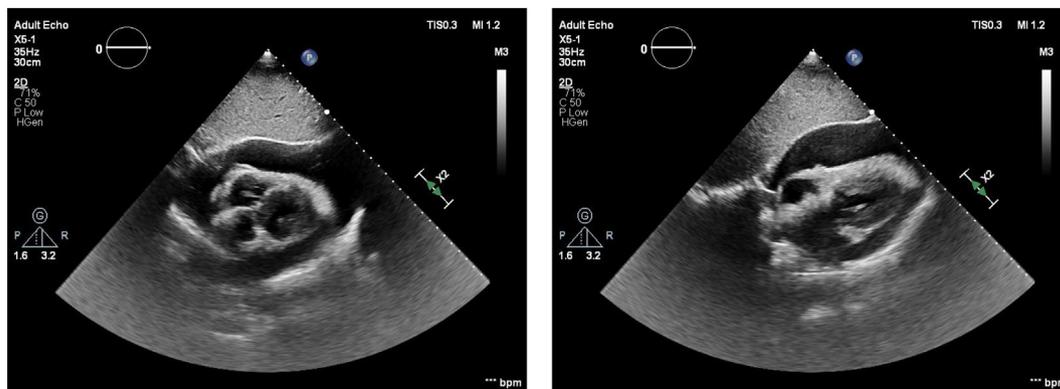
Transthoracic echocardiography demonstrating a large, circumferential pericardial effusion with right ventricular diastolic collapse.
